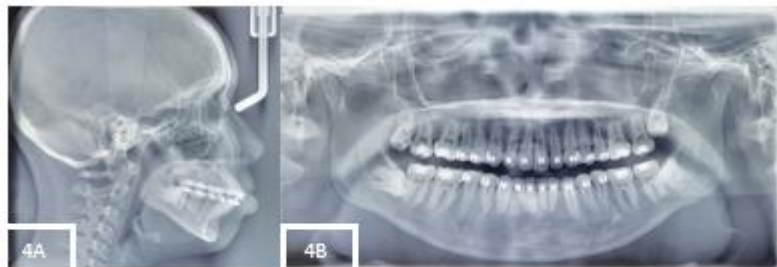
Post-treatment cephalometry radiograph (Fig.4A) and panoramic radiograph (Fig.4B).
